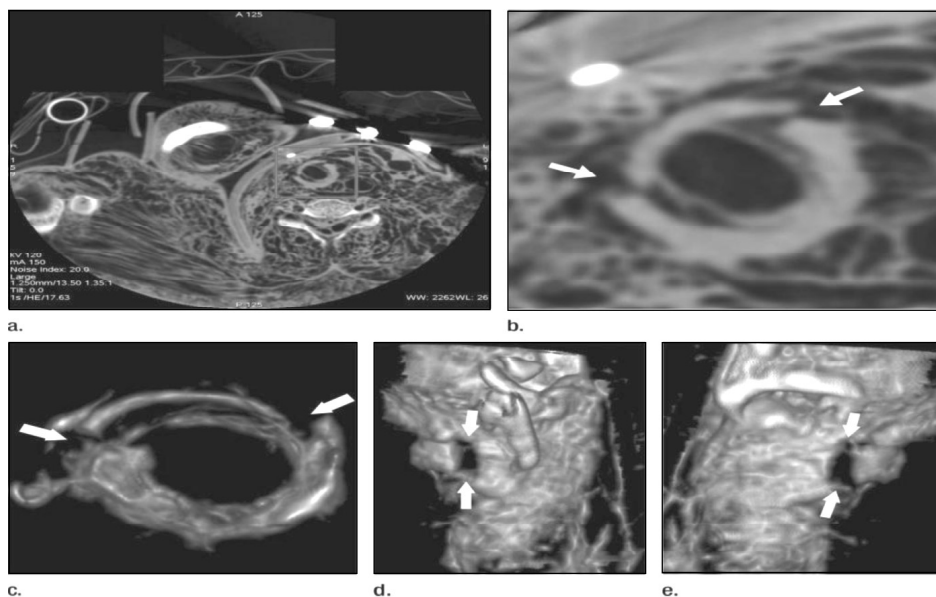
a: Axial cervical post-mortem CT scan; b: zoomed section of the cricoid cartilage (box in a) of a 27 year-old woman who died of strangulation. Three-dimensional volume rendered reconstructions from cranial; c: left lateral oblique; d: right lateral and e: oblique views.
